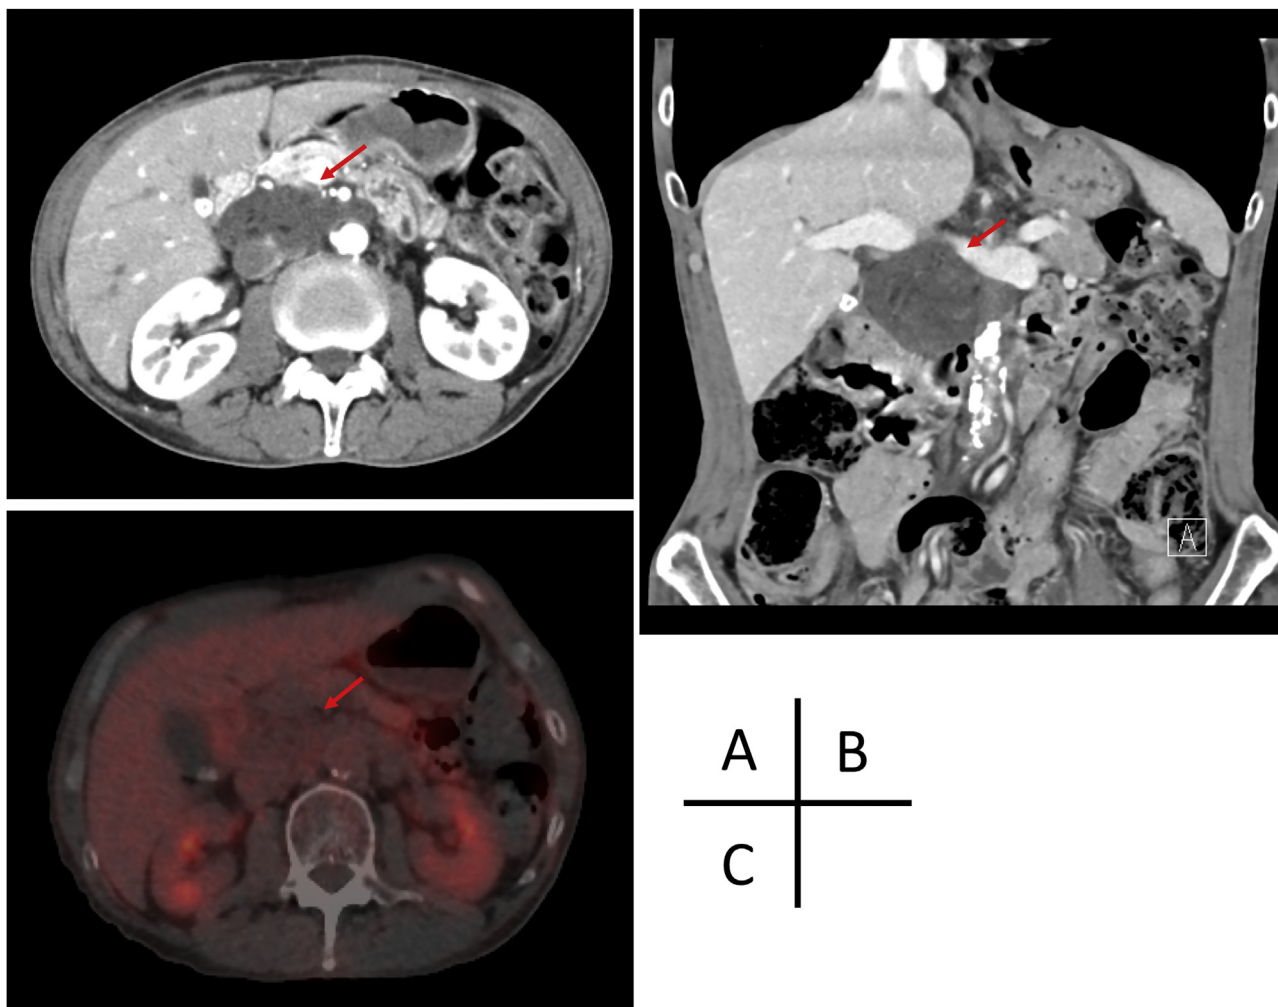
Computed tomography (CT) shows a well-defined round, 66 × 47 mm cystic and solid mass with a rim of soft tissue in the retroperitoneal region and dorsal of the pancreatic head. Slight enhancement of the peripheral rim of soft tissue is seen after intravenous administration of the contrast medium (A: axial image, B: coronal image). This tumor has low fluorodeoxyglucose (FDG) uptake on positron emission tomography (PET) (C).
